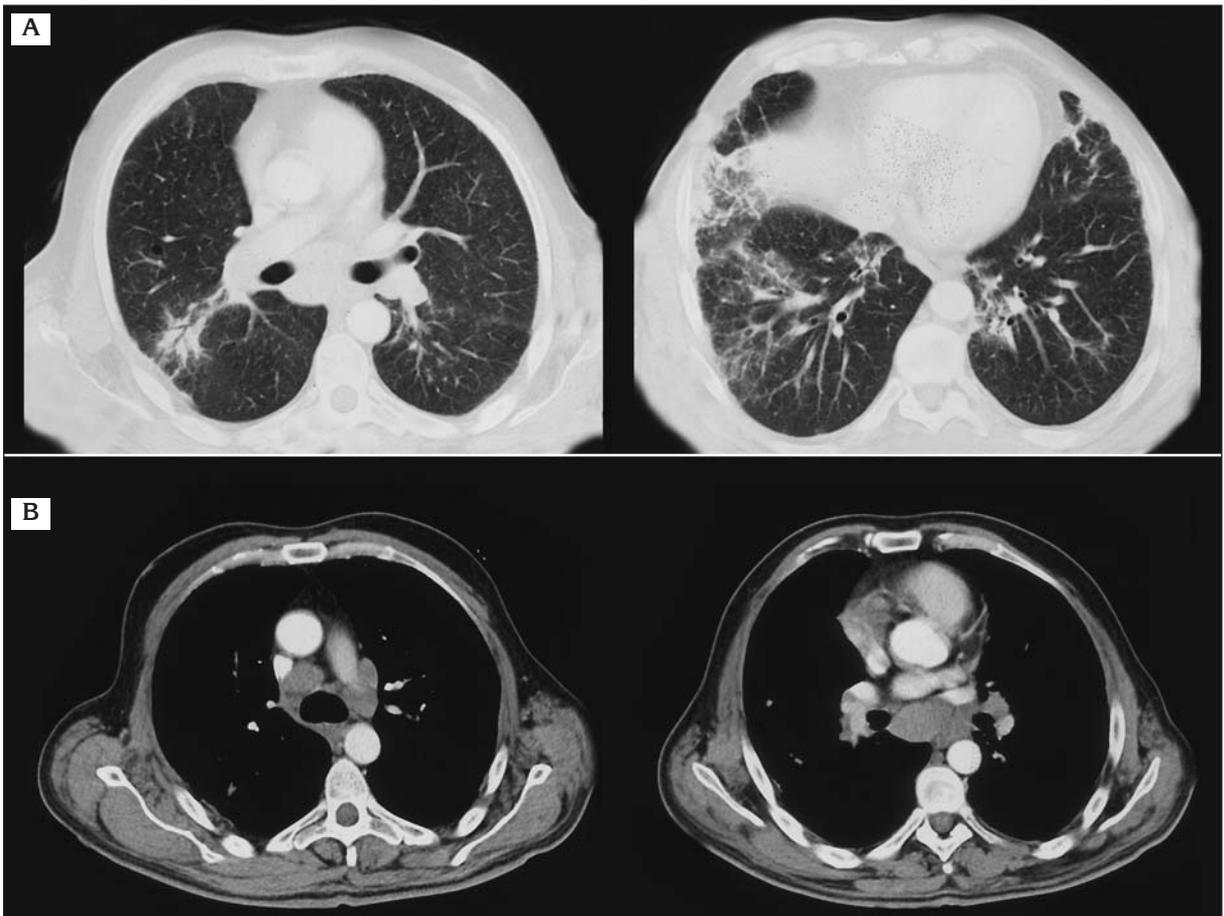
CT scan of the lungs demonstrating (A) translucent densities, consolidations, reticular opacities and subpleural milimetric cystic spaces in both lungs, particularly in the right and (B) mediastinal hilar and subcarinal lymphadenopathy.
